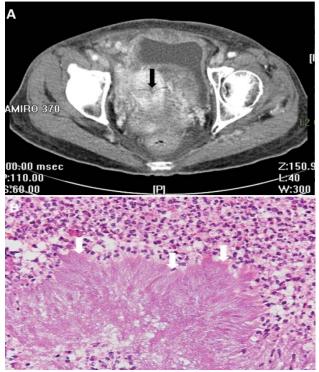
(A) Computed tomography of abdomen revealed inflammatory change of pelvis with multi-focal abscess around a non-radiopaque intrauterine device (black arrow), (B) The pathologic examinations revealed an organized aggregate of filamentous bacteria surrounded by suppurative inflammation (white arrows)
